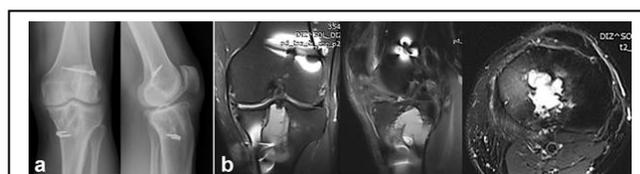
Preoperative anteroposterior and lateral radiographic views of the knee joint (a), MRI sequences of the tibial cyst (b).
